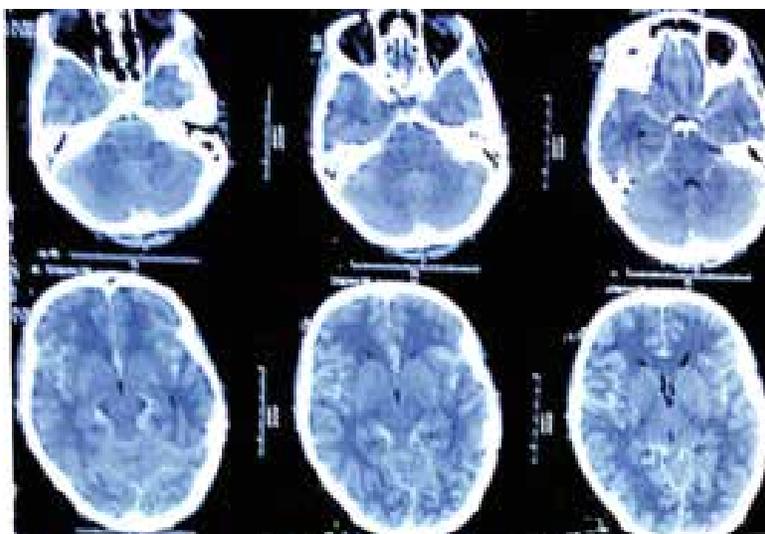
CT Brain plain showed hyperdense areas (sub arachnoid haemorrhage) more prominent around circle of Willis.
